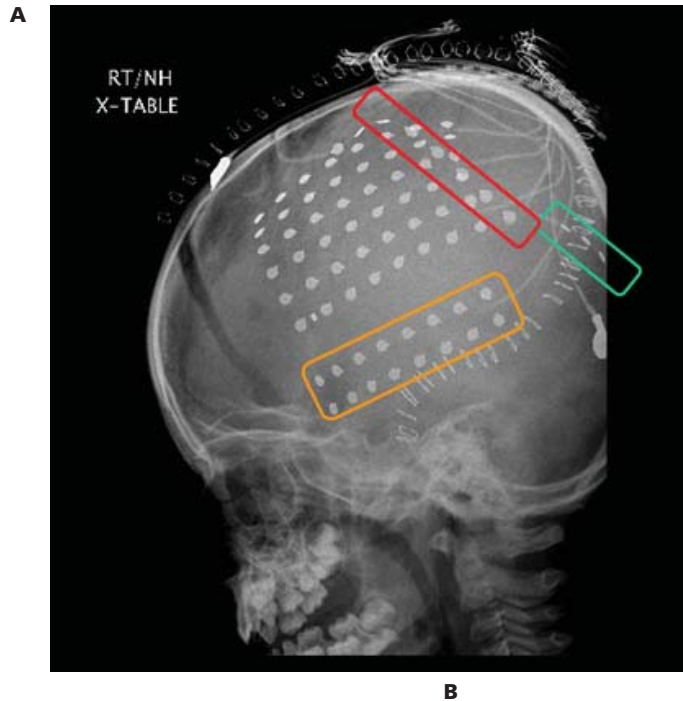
a. Lateral skull x-ray revealing subdural electrodes consisting of a 48-contact grid over right frontoparietal cortex, a 16-contact grid over right temporal cortex (orange), and two 8-contact strips over the interhemispheric region (red) and occipitotemporal cortex (blue). b. EEG showing seizure onset with a burst of high-amplitude paroxysmal discharges in the right temporal region (arrow, surrounded by purple line), followed by widespread suppression of background activity throughout the convexity (green).
